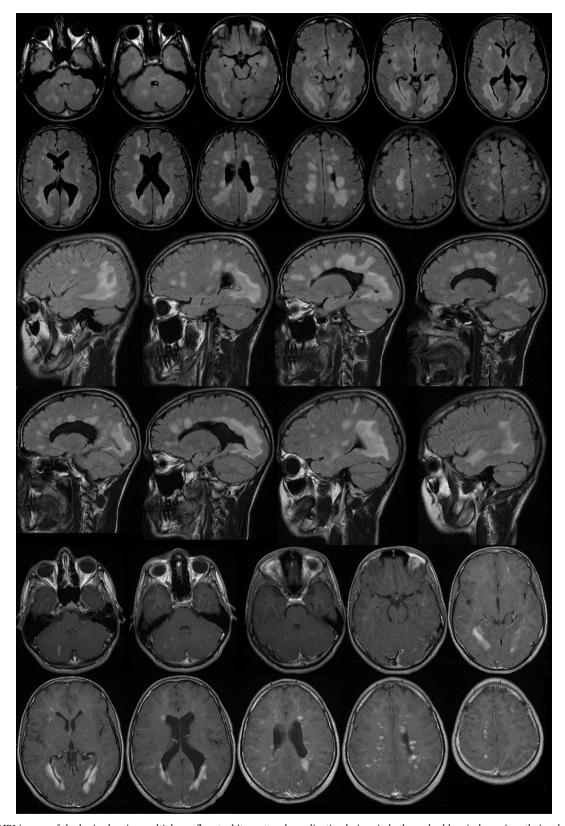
FLAIR MRI images of the brain showing multiple confluent white matter demyelinating lesions in both cerebral hemispheres (mostly involving the parietal and occipital lobes), corpus callosum, cerebellar hemispheres, and dorsal pons. These lesions demonstrated nodular and linear enhancement in contrast-enhanced T1 images.
